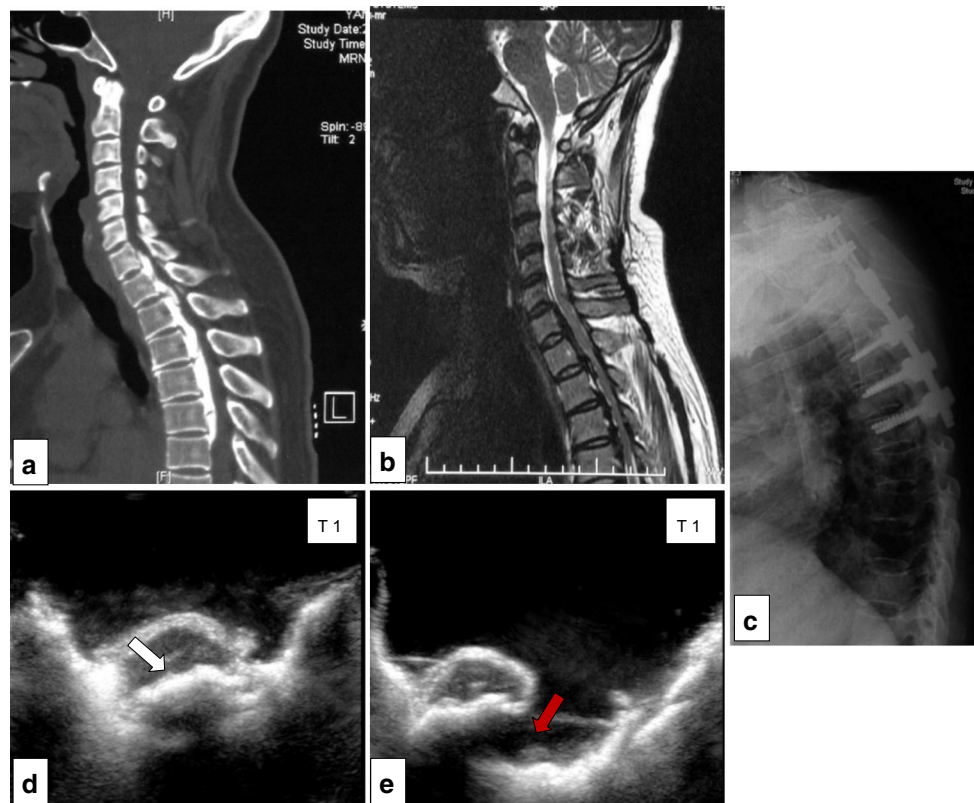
Presentations of a 43-year-old female, who suffered wheel-chair dependence and occasional urinary incontinence but maintained hand functions intact. Her preoperative JOA score was 11.0. a, b Displayed the continuous compression from C6 to T6 OPLL and miscellaneous signals inside the spinal cord. She underwent one-staged decompression, laminectomy with lateral-mass fusion at C6–C7 and laminectomy with pedicle-screw fusion at T1–T6 (c). After laminectomy, the backward shift of spinal cord was unsatisfactory and ultrasonography revealed the persisting of severe anterior compression at T1–T3 (white arrow in d). Circumferential
